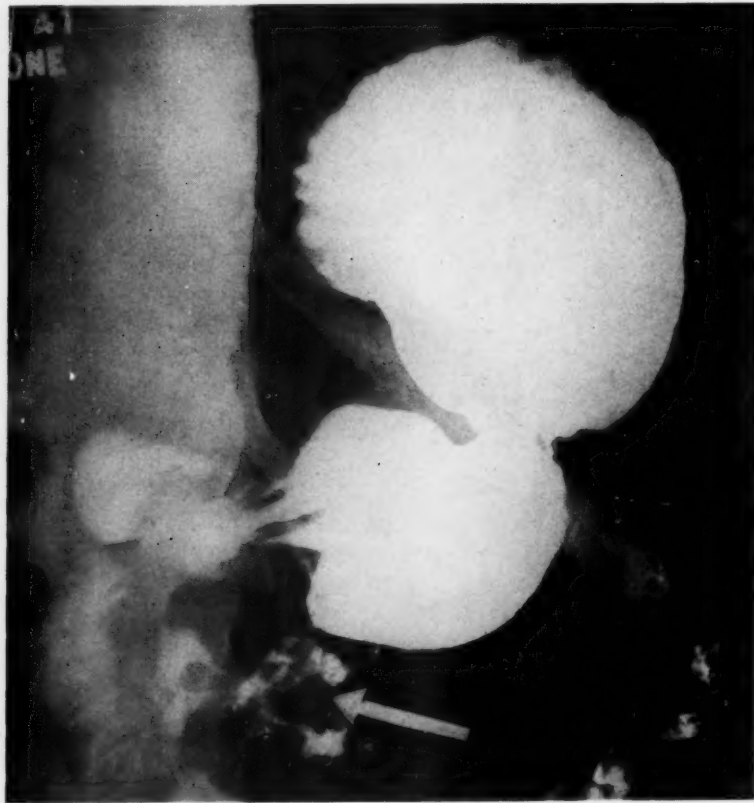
Roentgenogram of the stomach and duodenum. Arrow points to the Y-shaped irregularity in distal duodenum, which corresponds to the crater of the actual lesion.
